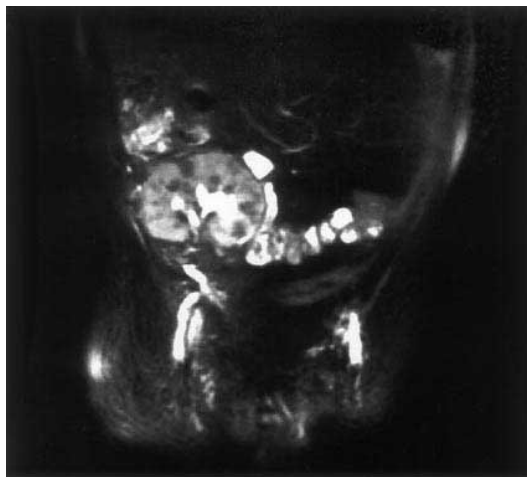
T2-weighted coronal magnetic resonance imaging scan with fat saturation shows multiple low-attenuation lesions throughout the parenchyma of the renal allograft.
